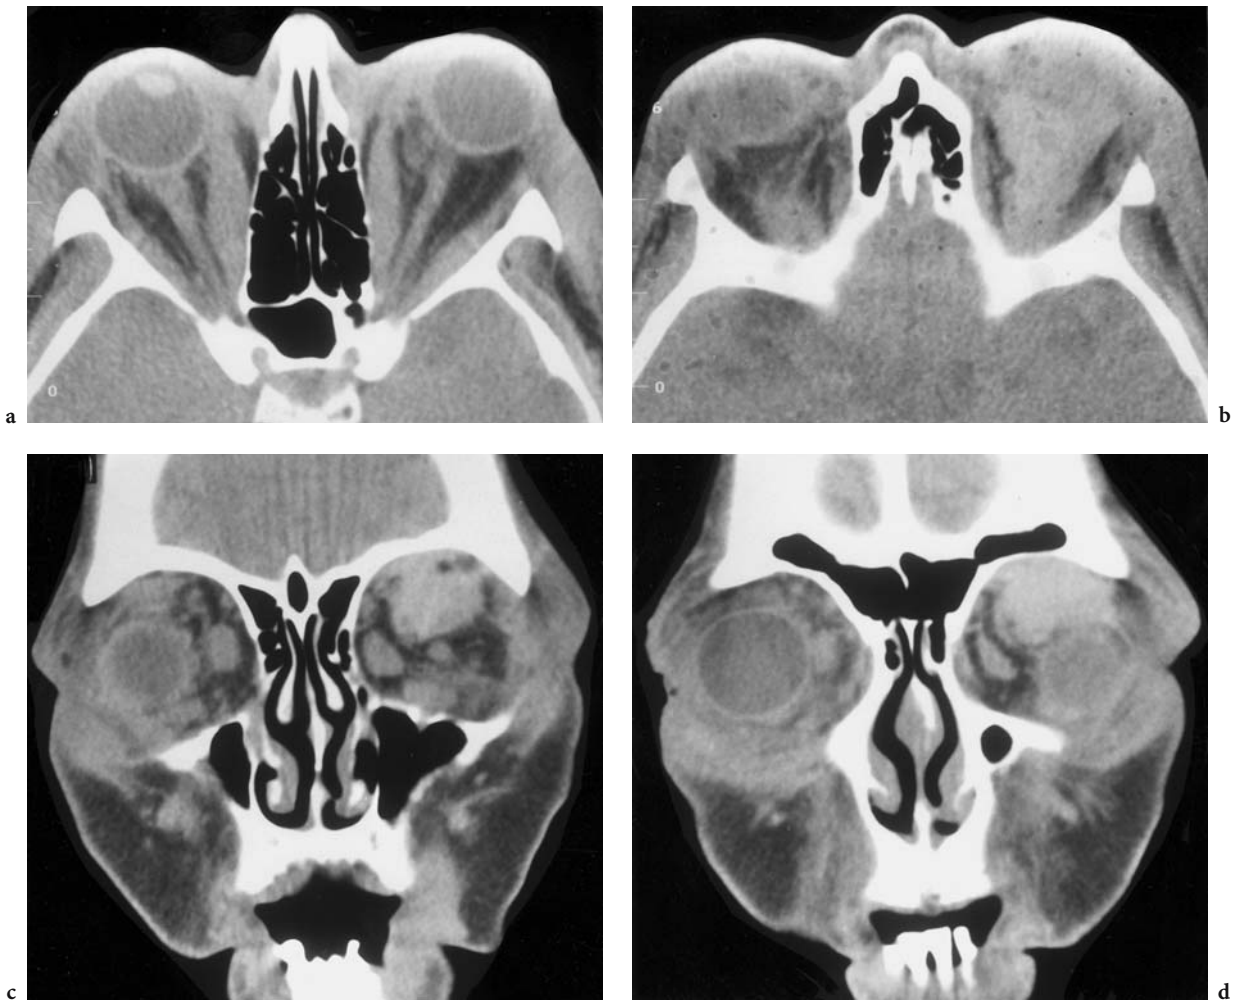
A 51-year-old woman with known Graves disease. One day after operative fat resection of the left eye, the patient developed acute deterioration of the severe proptosis (right: 29 mm, left 33 mm), but no visual deficit. Diagnosis: acute retrobulbar hemorrhage (as an operative complication). CT: a Axial, native view of the medial orbit, where demonstrating bilateral severe proptosis and inferior dislocation of the left globe. b Axial view of the upper orbit with hyperdense mass in the region of the left superior muscle complex. c Coronal view of the region of the posterior globe where the hyperdense hemorrhage is seen, apparently involving the superior rectus muscle. d Coronal view of the anterior orbit, demonstrating best an inferior dislocation of the protruded left globe by the space-occupying hemorrhage
